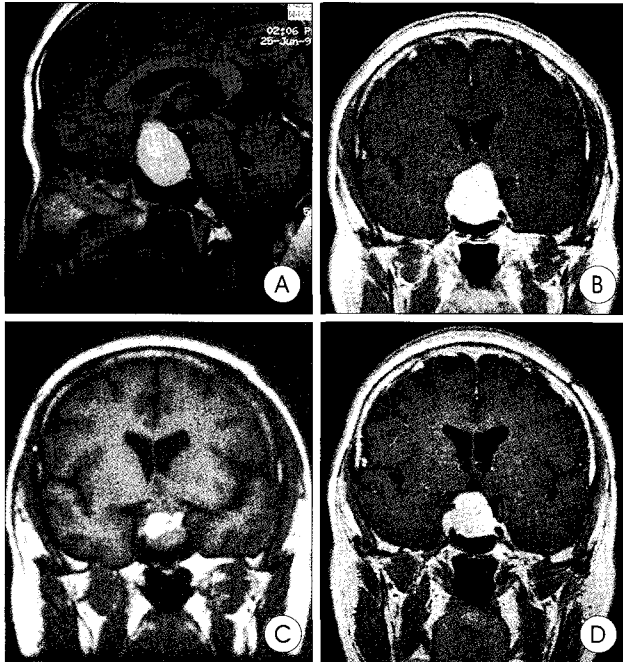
Serial magnetic resonance images. A, B : Preoperative magnetic resonance images showing a sellar and suprasellar solid mass. C : Postoperative magnetic resonance image showing a remnant mass and packed fat tissue. D : Magnetic resonance image taken 9 years after operation and radiotherapy showing a recurrent tumor arising from the pituitary fossa.
